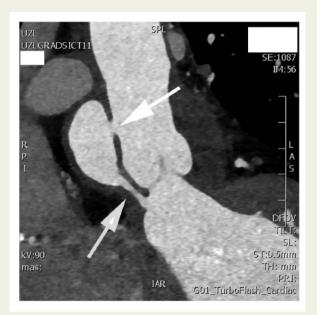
Figure I Contrast computed tomography demonstrating large pseudoaneurysm of the aortic root with entry above the right coronary artery (white arrow) and fistula originating from the base of this pseudoaneurysm, connecting with the left ventricular outflow tract (speckled arrow).
